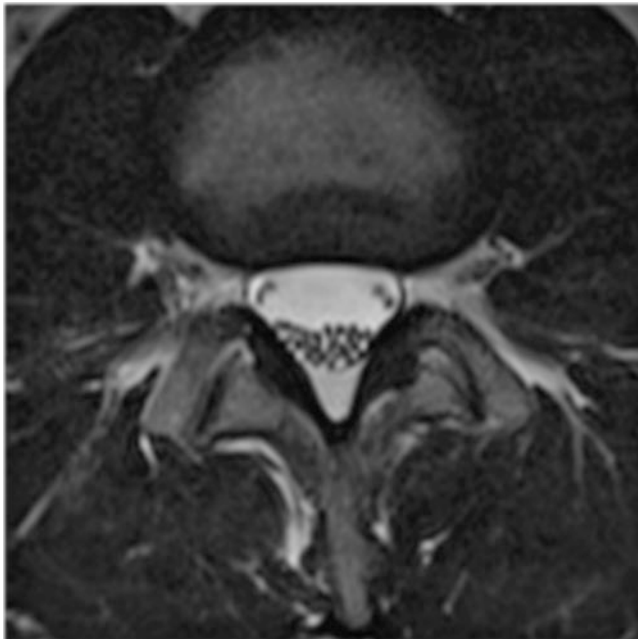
Magnetic resonance imaging of lumbar spine. Axial T2-weighted image demonstrates the dorsal and lateral epidural space (Acknowledgement of Dr. Alex Schabel)
